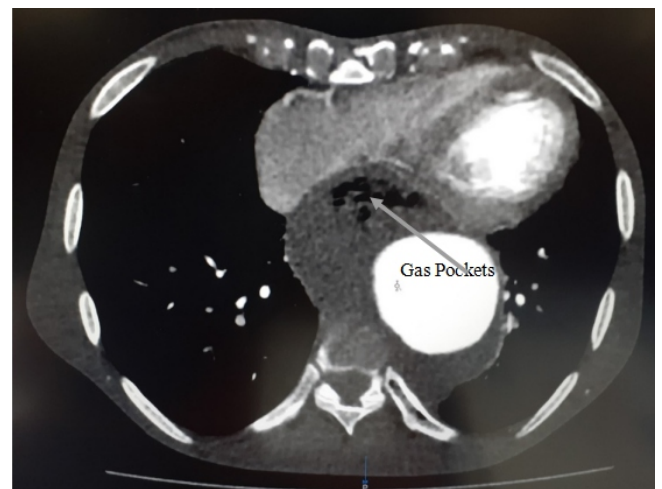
CT chest showing gas pockets around the aneurysm
